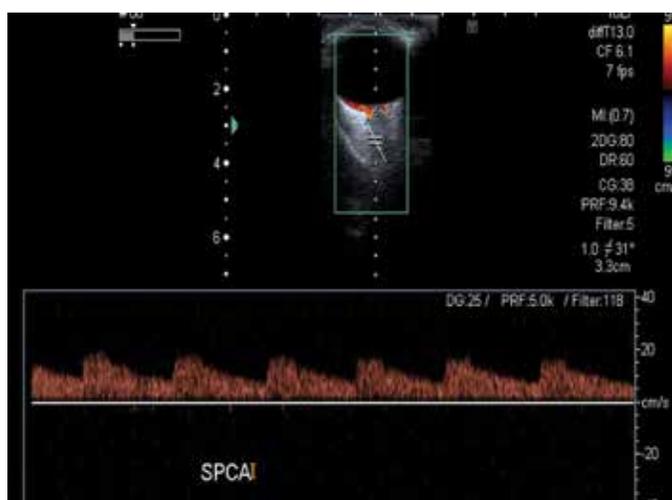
Color Doppler Imaging of Short Posterior Ciliary Artery and characteristic waveform
